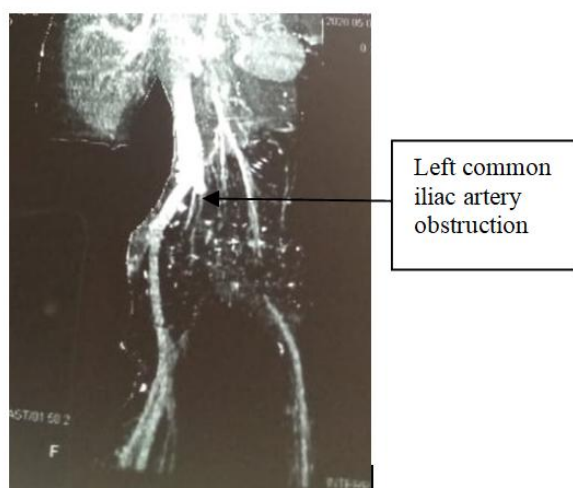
Coronal CT angiography, showing left common iliac artery obstruction.
